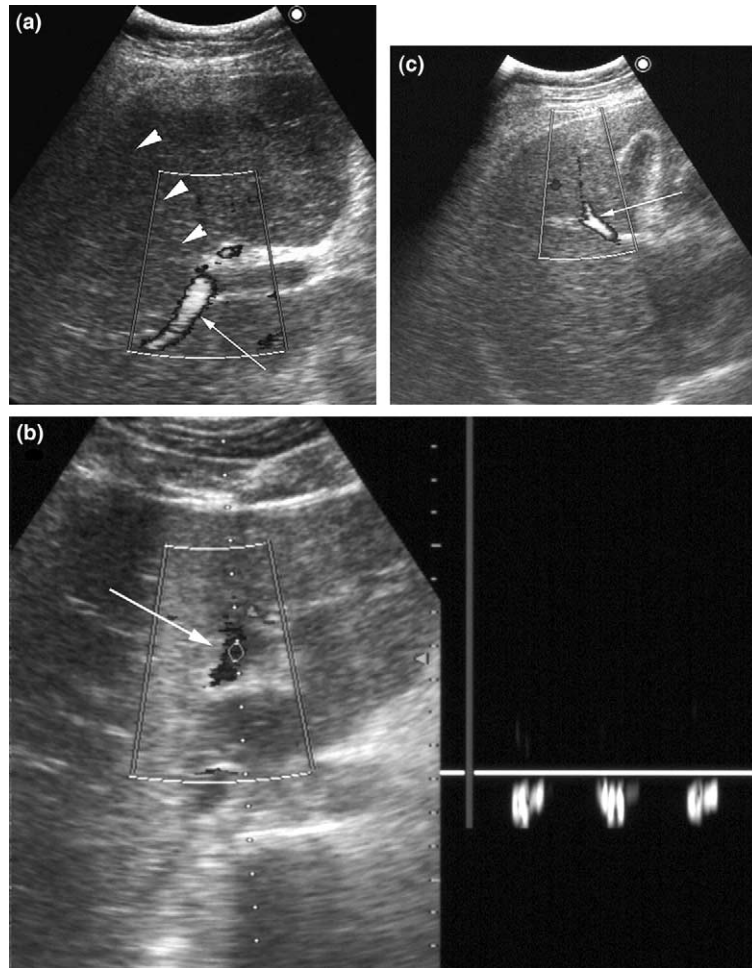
15-year-old boy with stage IV Ewing's tumour of the left ilium (patient No. 2). Power and pulsed Doppler US (a–b) performed during high-dose chemotherapy using the combination of busulfan and melphalan complicated by HVOD. US shows the lack of visualisation (a) of the anterior segmental right portal branch (arrowheads), while the posterior branch (arrow) is clearly identified, and (b) abnormal reverse flow in the left main portal branch (arrow), while flow in the portal trunk was still hepatopetal (data not shown). Power Doppler US (c) performed 3 weeks after symptomatic treatment of HVOD and isocoagulant heparin therapy shows normal permeability of the portal veins, including recovery of a normal flow within the anterior segmental right portal branch (arrow), together with resolution of the clinical, laboratory and ultrasound signs of HVOD. The child is currently in first complete remission, 33 months after completion of treatment and presents no signs of PHT.
